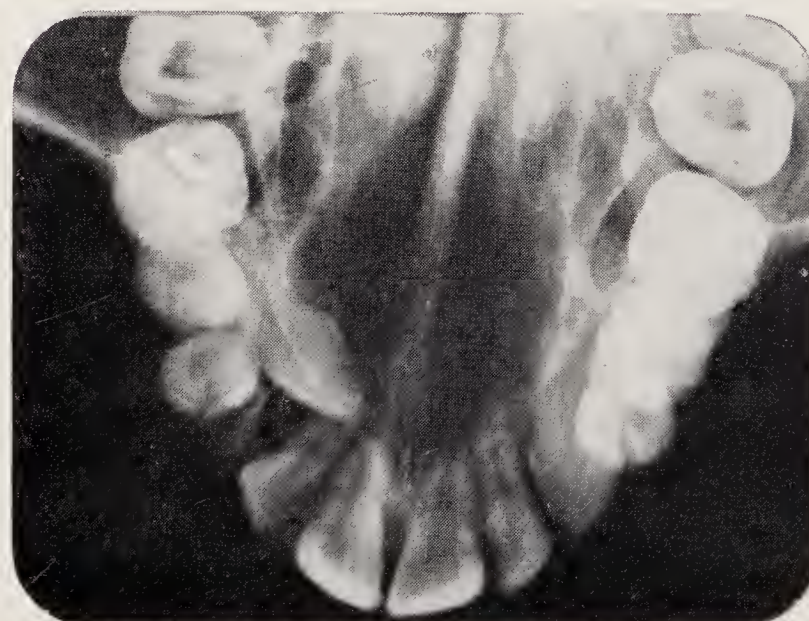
Radiographs to show result of treatment to move $\bar{3}$ into position. Tooth was impacted against buccal aspect of $\bar{2}$. A pin was inserted from a buccal approach and tooth was moved into position with the aid of a fine wire spring.
